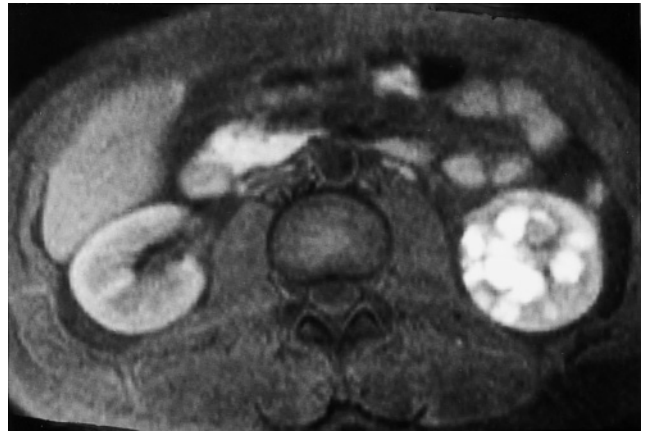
Multilocular cystic nephroma. Coronal T2-weighted SS-ETSE (a) and transverse T1-weighted 90-s fat-suppressed gadolinium-enhanced SGE (b) images. A well-defined cystic mass arises from the posterior aspect of the right kidney. Internal septations are present, which are low in signal intensity on the T2-weighted image (arrow, a) and enhance on the post-contrast T1-weighted image (arrow, b). The lesion is noted to bulge into the renal pelvis. These imaging features are typical for multilocular cystic nephroma. This location is also common, arising in the posterior cortex of the kidney at the midrenal level. T1-weighted precontrast fat-suppressed SE (c), T1-weighted immediate postgadolinium SGE (d), and T1-weighted fat-suppressed gadolinium-enhanced SE (e) images in a second patient with multilocular cystic nephroma demonstrate a similar-appearing cystic mass that bulges into the renal pelvis and contains enhancing internal septations. Note that the cyst contents are intermediate in signal intensity on the precontrast T1-weighted image (c).
